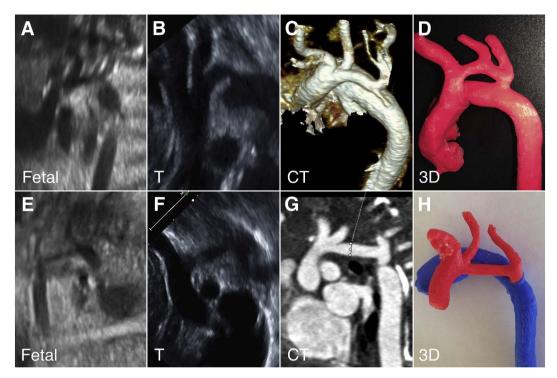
Arch conformation (discrete coarctation vs. arch hypoplasia) as viewed on fetal echocardiogram (A vs. E), transthoracic echocardiogram (B vs. F), cardiac CT (C vs. G), and 3D cardiac print (D vs. H).
